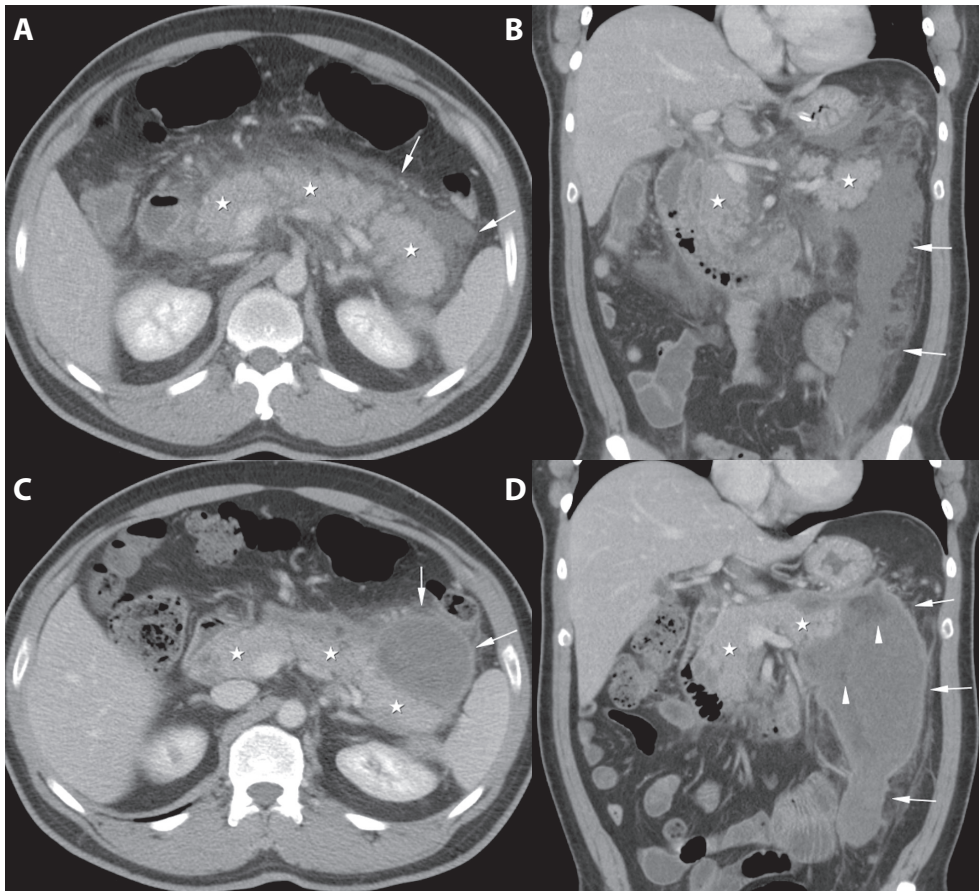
Extrapancreatic necrosis. (A, B) Axial and coronal reconstructed contrast-enhanced CT scans in a 37-year-old man with alcohol-induced pancreatitis 6 days after onset of symptoms. There is normal enhancement of the pancreatic parenchyma (white asterisks) with a poorly margined peripancreatic collection (arrows) extending into the left anterior pararenal compartment. (C, D) Axial and coronal reconstructed contrast-enhanced CT scans 2 months later, again showing a normal enhancement of the pancreas surrounded by a well encapsulated heterogeneous peripancreatic collection (arrows) with areas of non-liquid (fat) densities (arrowheads) in the left anterior pararenal compartment. During surgery a large amount of necrotic material was debrided and pus was drained. The patient recovered uneventfully with preservation of normal pancreatic function.
